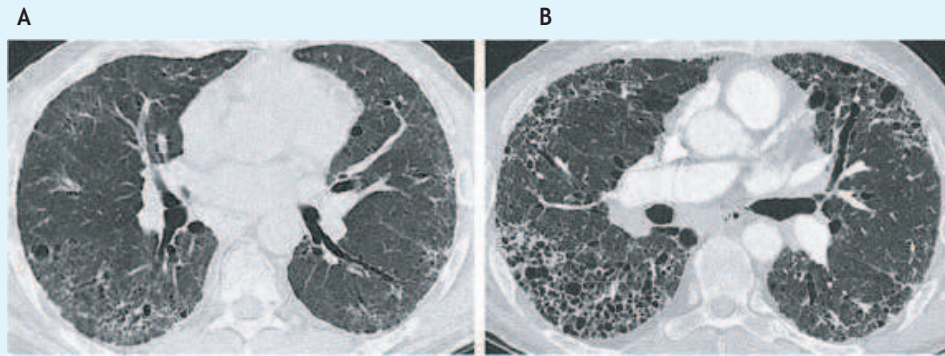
Serial high-resolution thoracic computed tomographic scans, 12 months apart, at a level just below the carina in a 63-year-old man with idiopathic pulmonary fibrosis (IPF). The scan at diagnosis (A) demonstrates subpleural reticular change with early honeycombing but an absence of ground-glass attenuation—an appearance typical of IPF. A scan 12 months later (B) discloses dramatic disease progression with the development of marked honeycomb change with associated traction bronchiectasis and architectural distortion.
